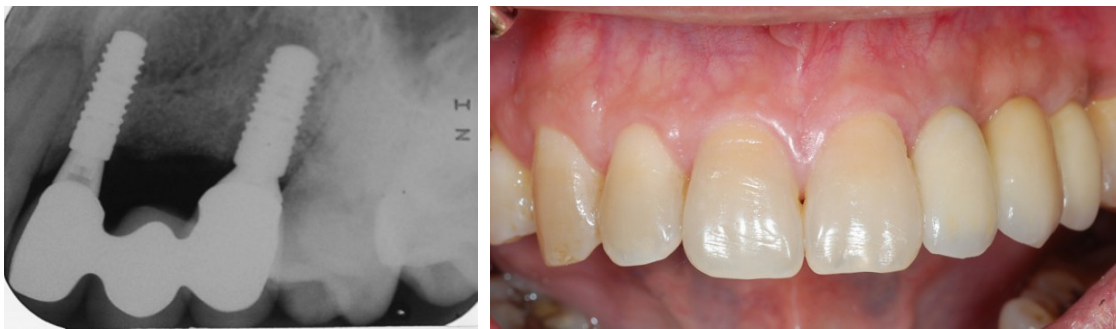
Radiographic examination revealing precisely parallel placement of implants
